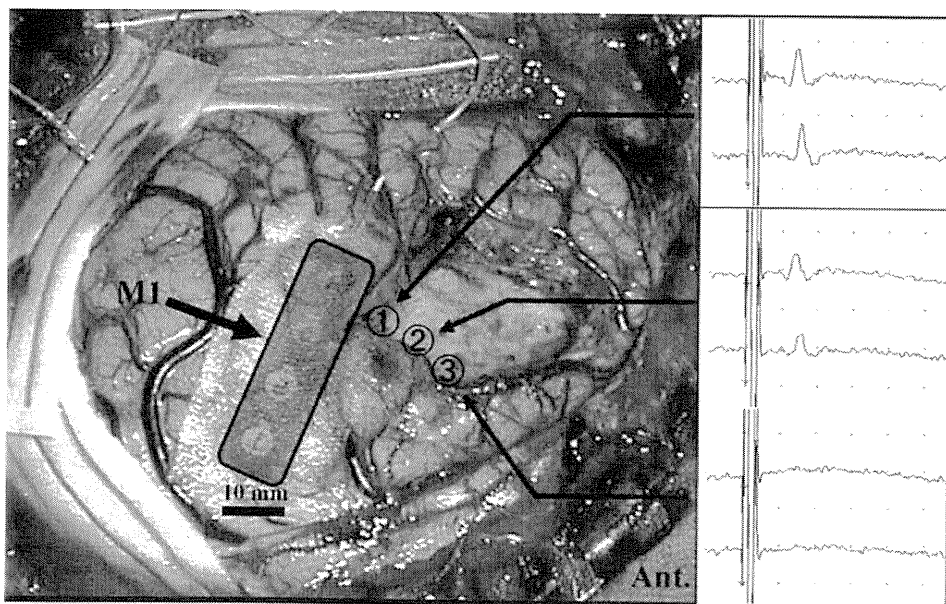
Intraoperative photograph shows that subcortical D-wave amplitude changes significantly depending on the distance between the stimulating point and M1 and/or CT.
